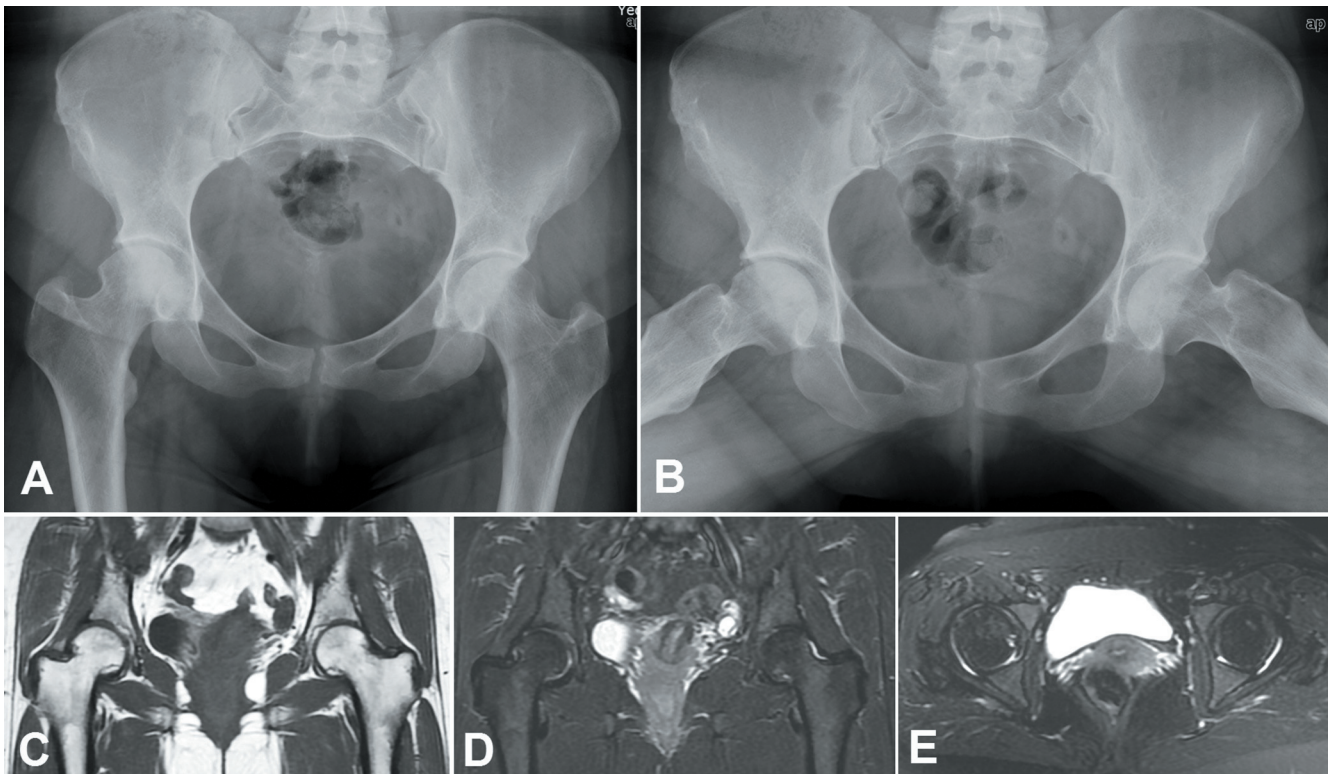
A-E. Radiographic evaluation of the same patient at 8th year postoperatively. On the anteroposterior (a) and frog-leg (b) radiographs of the pelvis, there is no evidence of joint space narrowing with minimal degenerative changes including osteophytes at the lateral part of the femoral head and superolateral acetabular rim. MRI scans of the pelvis (c-e) demonstrate complete reversal of the signal abnormalities. The normal contours of the femoral heads are well preserved.
